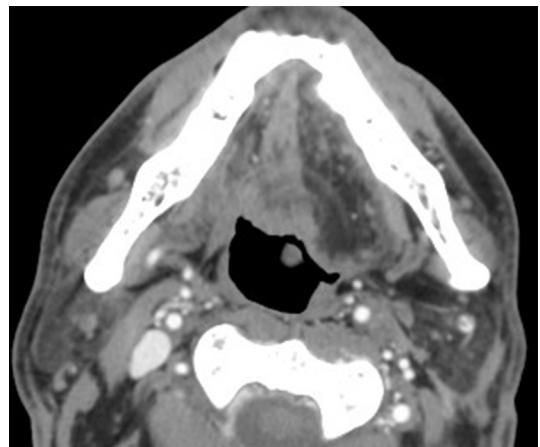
Fatty atrophy of the tongue from hypoglossal denervation. CT demonstrates asymmetry of density within the tongue, with a sharp midline demarcation. The left side of the tongue musculature has atrophied from injury to CN XII.
